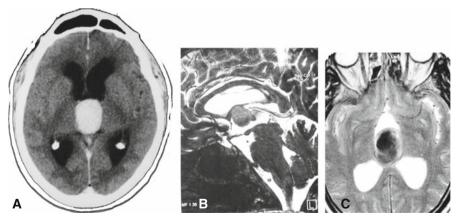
A Noncontrast CT scan of hyperdense colloid cyst. B Sagittal MR T2 view of isointense colloid cyst. C Axial T2-weighted MRI of hypodense colloid cyst
